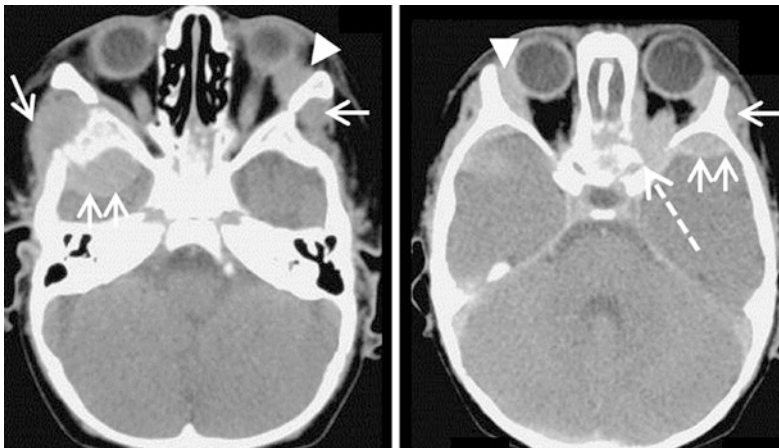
A 10-month-old boy with metastatic adrenal neuroblastoma (MYCN amplified, INSS stage 4, INRGSS M). Contrast-enhanced transverse CT scan views of the brain and orbits. Typical bone metastases occurring along bone fissures of the skull and facial bones. Soft tissue invasion is visible in the external temporal fossa (arrow), in the epidural space along the great sphenoid wings (double arrows) and in the orbit (arrowheads). Invasion of the left optic canal (dotted arrow) represents an emergency situation because of possible optic nerve compression
